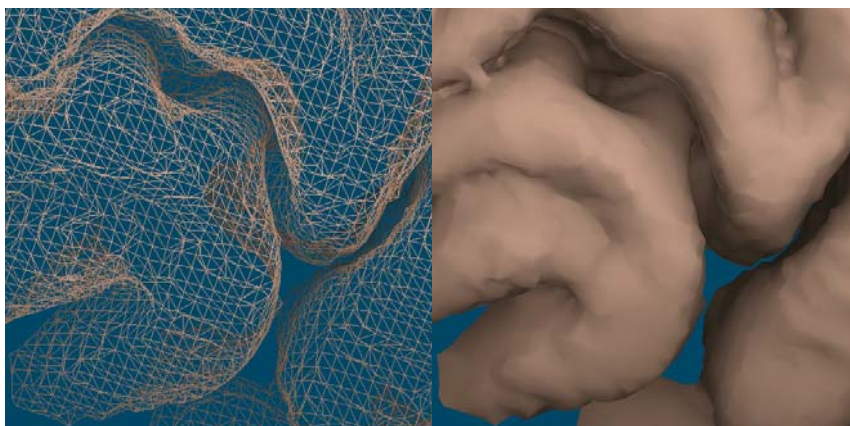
Triangulated (left) and shaded (right) portion of the brain from MRI, created with the marching-cubes algorithm
